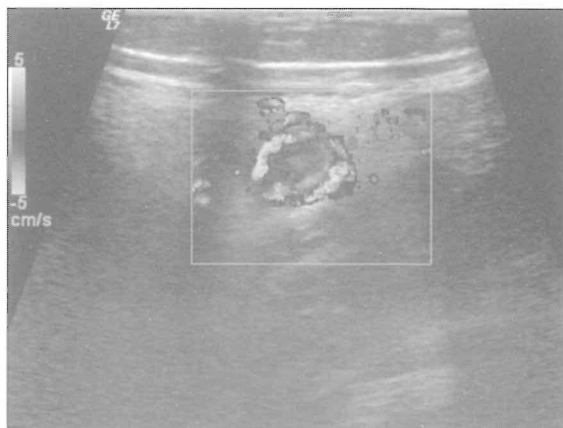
Transverse Doppler US shows increased vascularity of the appendix.
